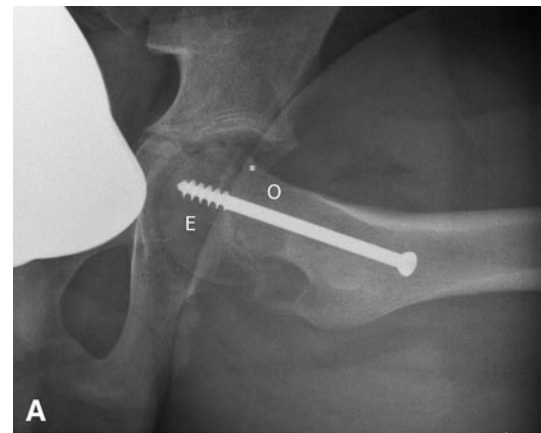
Frog-leg lateral hip radiographs demonstrate in situ pinning of the epiphysis (E) and head-neck osteoplasty (O). The proximal anterior metaphysis (*) is no longer prominent. (A) Left hip of Patient 2. (B) Corrected epiphyseal-metaphyseal offset of left hip of Patient 2. (C) Corrected alpha angle of the left hip of Patient 2. Dashed line = line along center of femoral neck; Line E = line along anterior epiphysis parallel to femoral neck; Line M = line along anterior metaphysis parallel to femoral neck; α = alpha angle.
